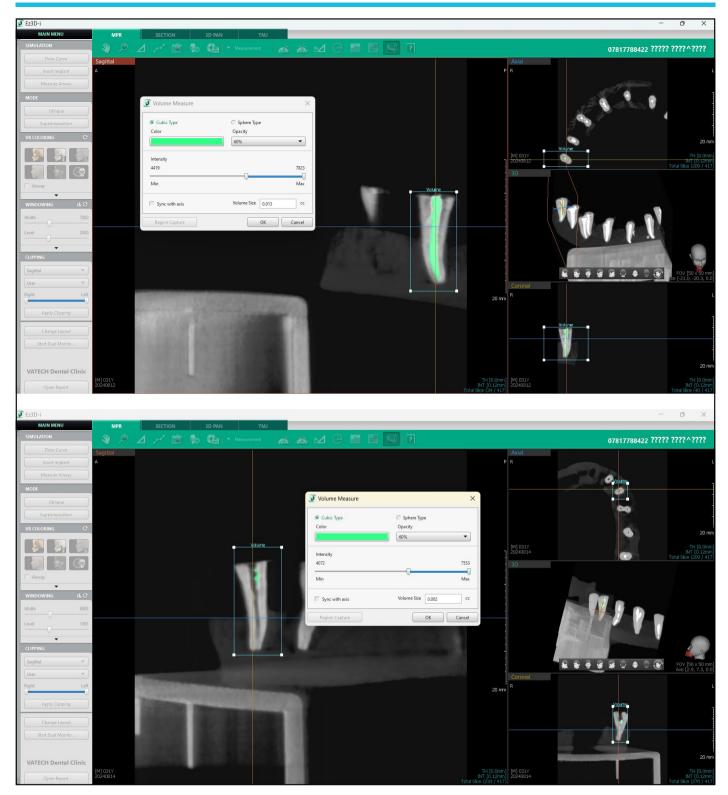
CBCT before and after retreatment with XP endo retreatment system for assessment of residual volume remanent. CBCT: Cone-beam computed tomography.
